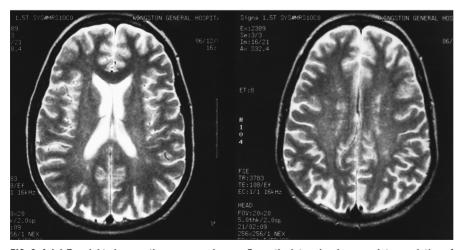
Axial T_c -weighted magnetic resonance images 5 months later showing complete resolution of the lesions seen on the initial brain scan (Fig. 1).
